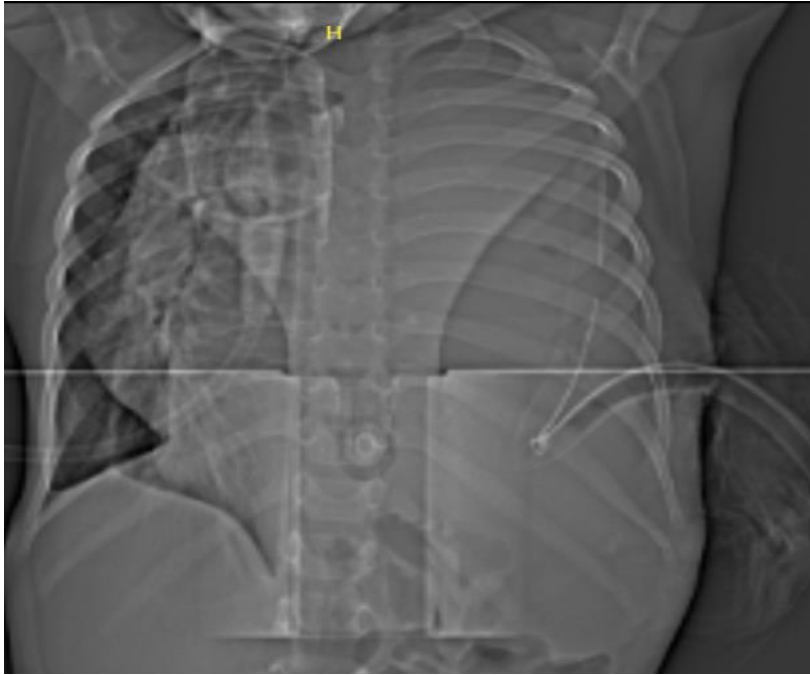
Frontal chest X-ray showing complete opacification of the left hemithorax, a chest tube that twisted and oriented upward.
